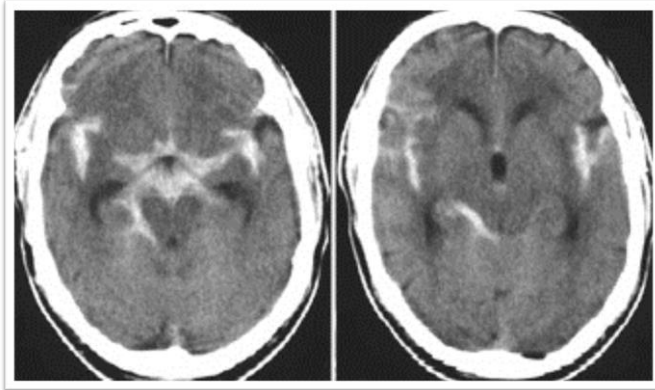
CT Scan on a patient with SAH.
